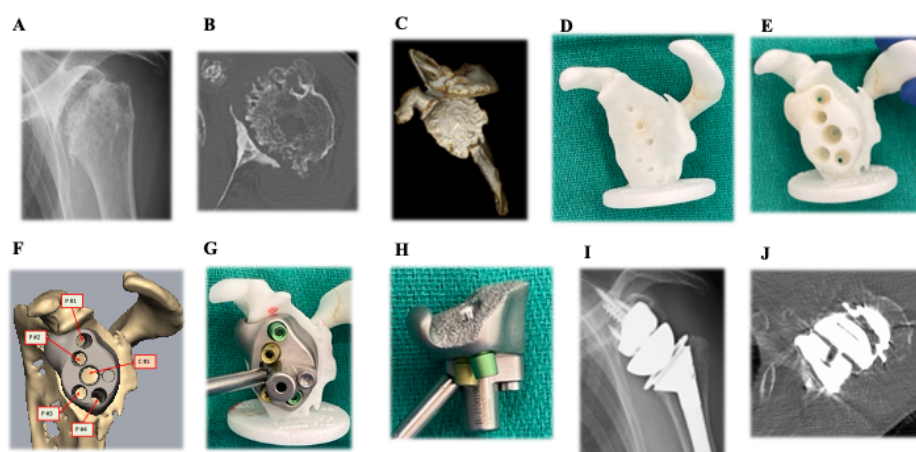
RSA with the VRS. (A) Preoperative X-ray AP view. (B) Preoperative CT axial image; Walch B3 glenoid. (C) 3D reconstruction image produced from CT scan. (D) 3D scapula bone model produced by 3D printer. (E) Prototype of VRS implant. (F) Proposal notification for screw insertion. (G) The final VRS implant with scapula bone model. (H) The VRS implant (the right side is anterior edge). (I) Postoperative X-ray AP view. (J) Postoperative CT axial image.
